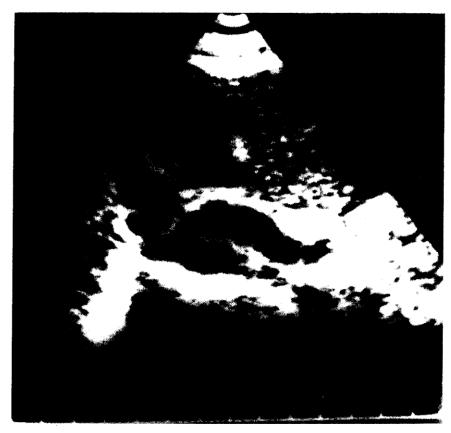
Ultrasound appearance of FCPD. Reproduced with permission from the *International Textbook of Diabetes Mellitus* published by John Wiley & Sons, Ltd. (see ref. 52).
